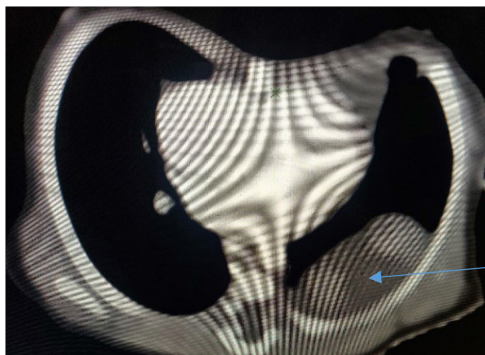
Contrast enhanced computed tomography (CECT) chest showing extralobar pulmonary sequestration (ELS).
